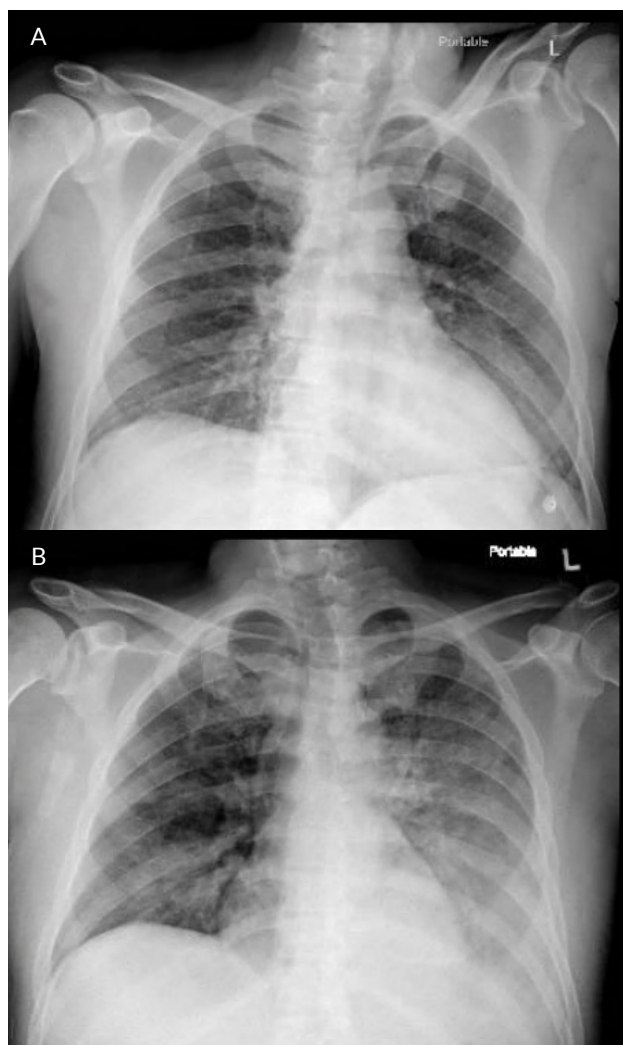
Chest X-ray on day 1 in the emergency department vs chest X-ray on day 6.
